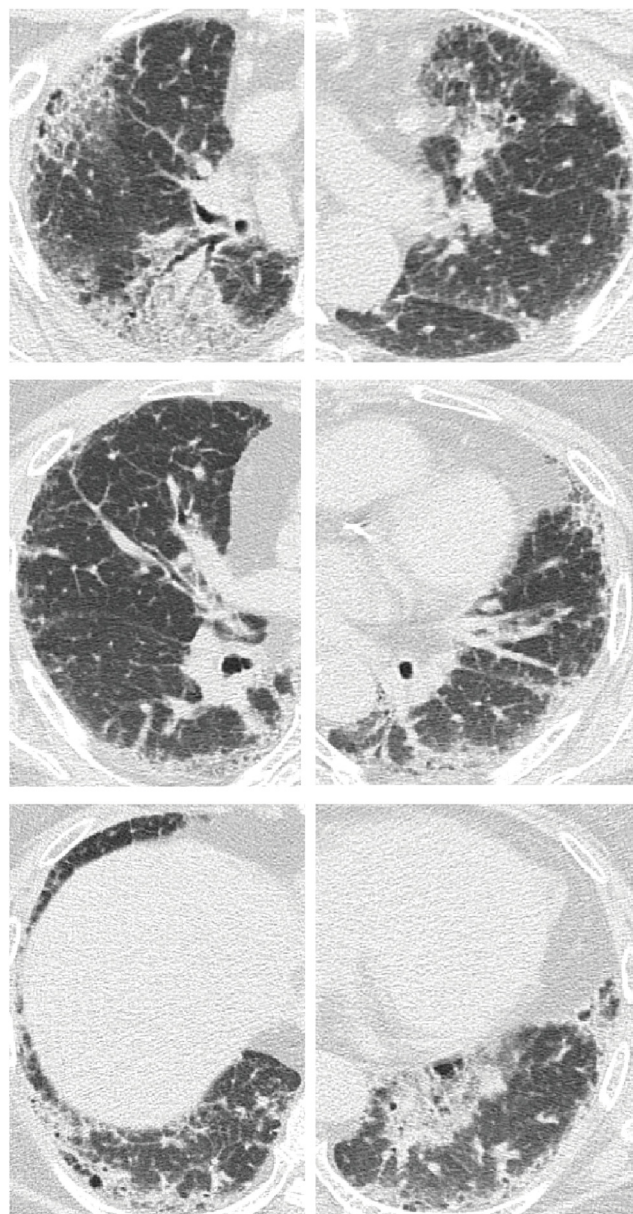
Chest computed tomography on first admission.
